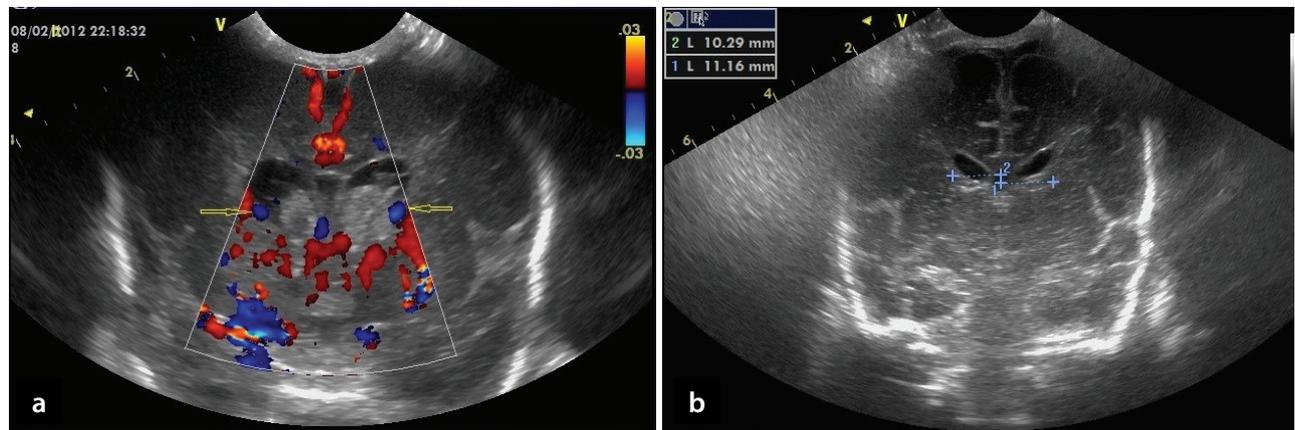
Neonate 29 GWs with bilateral IVH Grade III and haemorrhage in the 3rd ventricle: a. Colour Doppler image. Bilateral TVs are demonstrated, patent though displaced (arrows). b. Gray-scale coronal image of the same neonate six weeks later. The bilateral IVH has regressed.
